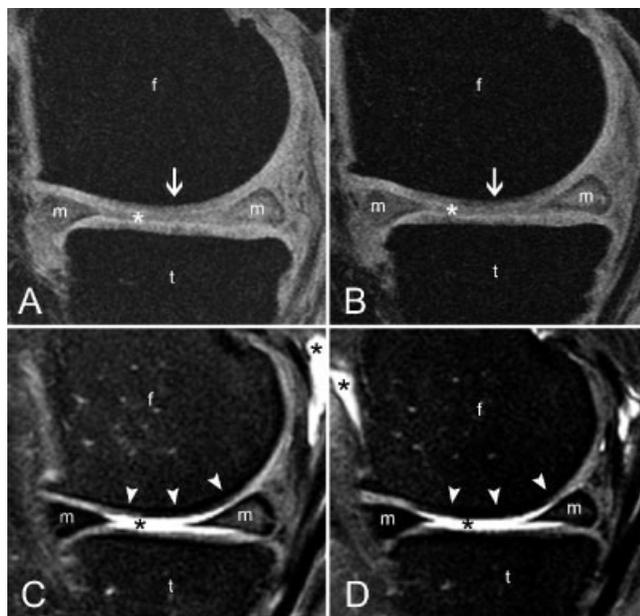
Representative magnetic resonance images of the same knee in the sagittal plane taken at the same level (medial central condyle) in gradient-echo (A and B) and intermediate-weighted fast spin-echo (C and D) sequences. The images show a cartilage defect of A, grade 3 at baseline (arrow), B, grade 4 at 2 years (arrow), C, grade 4 at baseline, and D, grade 5 at 2 years. C and D show the partial volume effect of the bright synovial fluid in the joint space outshining to the top layer of the cartilage surface (asterisks), which is not seen in A and B (asterisks). C and D also show the bone–cartilage interface of the deep calcified layer obscuring the interface by a thick black line (arrowheads). f = femur; t = tibia; m = meniscus.
